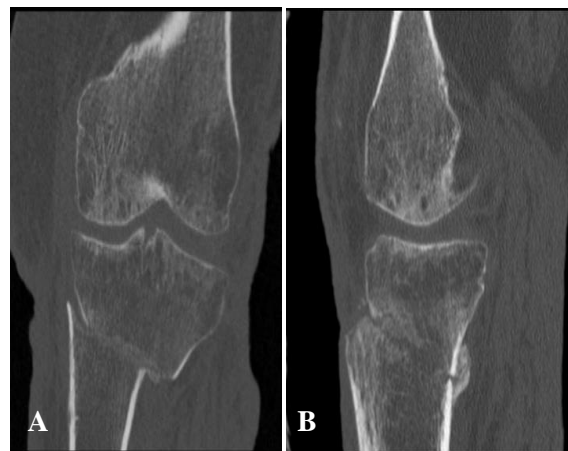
(A) AP, CT Scan 3 months later, showed some signs of fracture healing; (B) Lateral, CT Scan 3 months later, showed some signs of fracture healing.
